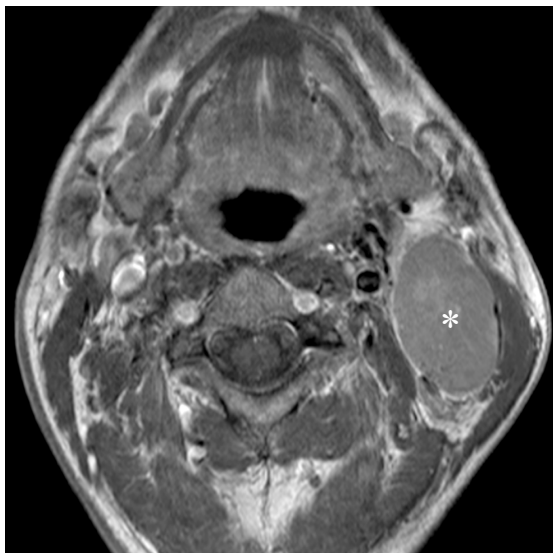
Axial Post-Gd T1W MRI shows a large nodal metastasis at the left jugulodigastric region (*).
